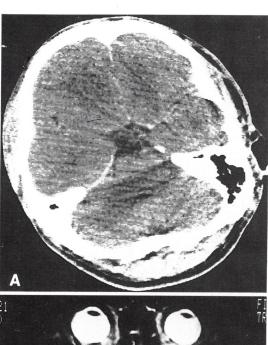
Brain CT of Case 3 shows a lacune in the right pons, while MRI reveals an additional ischemic lesion (arrow) in the left.
